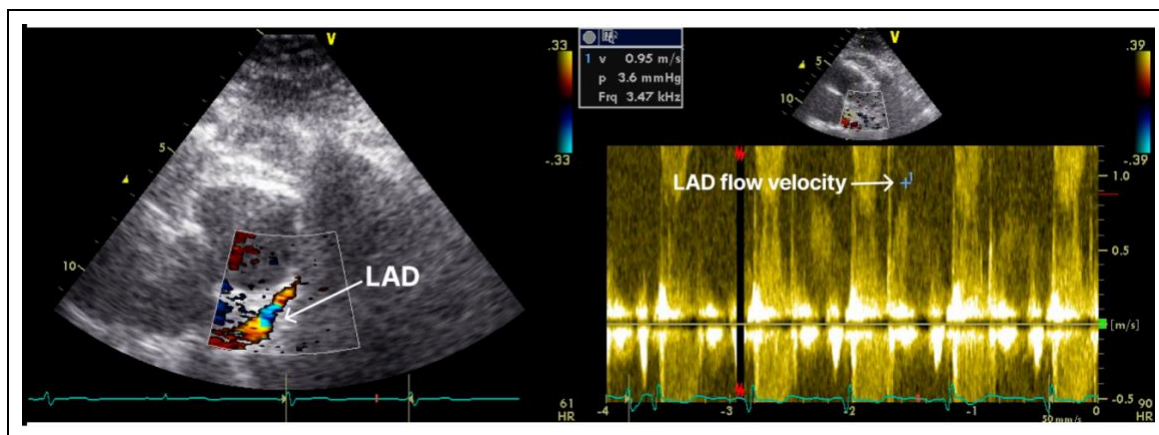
Increased coronary flow velocity in the proximal left anterior descending artery in Case 3: Color Doppler visualization of the left anterior descending artery (LAD) demonstrates turbulent flow. Pulsed-wave Doppler shows elevated resting diastolic flow velocity, suggesting significant proximal LAD stenosis later confirmed by coronary angiography.
